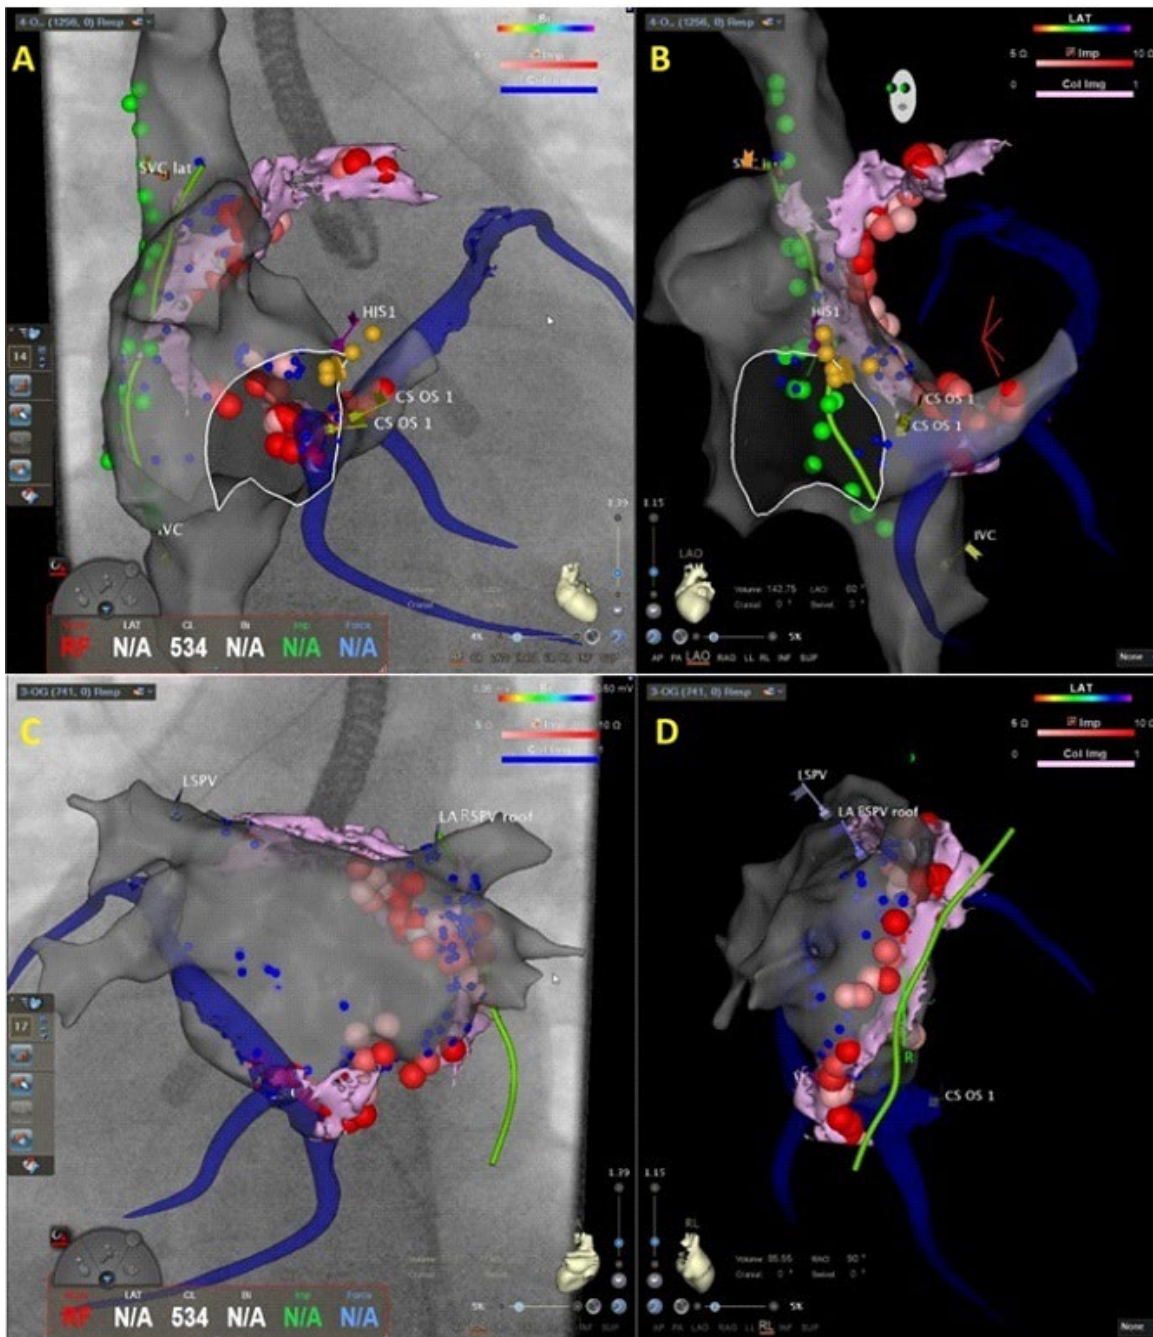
Integration of a cardiac CT scan with fat pad segmentation and GP anatomy, processed using InHeart software, combined with an electroanatomic CARTO map of the right atrium (A and B) and left atrium (C and D). The green line shows the right phrenic nerve, and the green dots indicate points of stimulation of this nerve by electrophysiology. The yellow dots represent the His bundle. The blue structures represent the venous coronary system. The red dots mark the ablation sites targeted by radiofrequency. The purple structures represent fat pads. CS= coronary sinus; OS = ostium; SVC = superior vena cava; lat = lateral; LSPV = left superior pulmonary vein; LA = left atrium; RSPV = right superior pulmonary vein.
